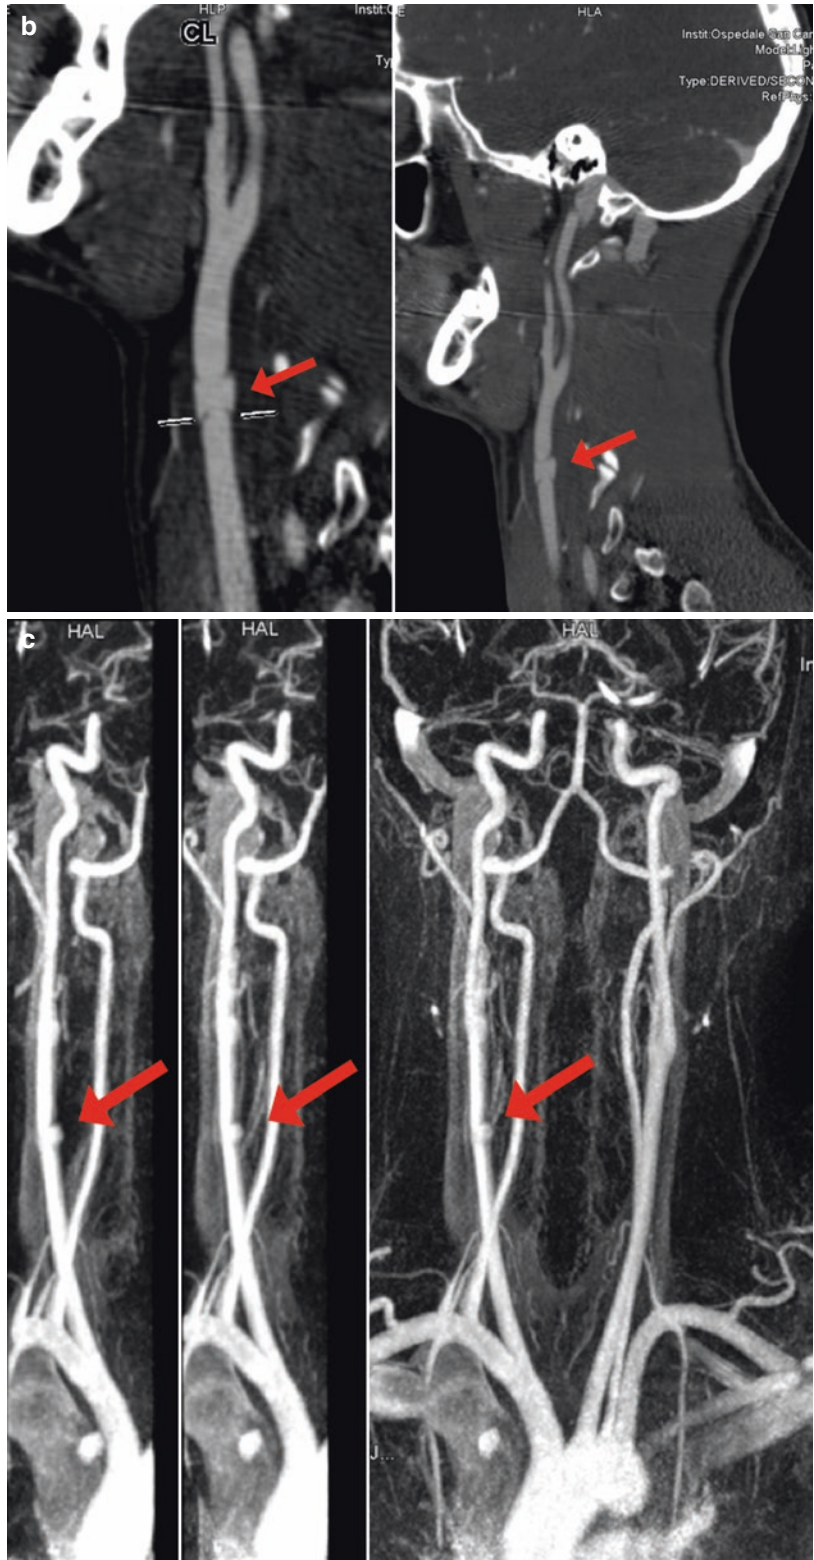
Traumatic partial dissection of the right common carotid artery after a blow with the elbow during a sports activity. Axial CT images (a), multiplanar (MPR) curve reconstruction; magnetic resonance (MR) examination control (b, c)
